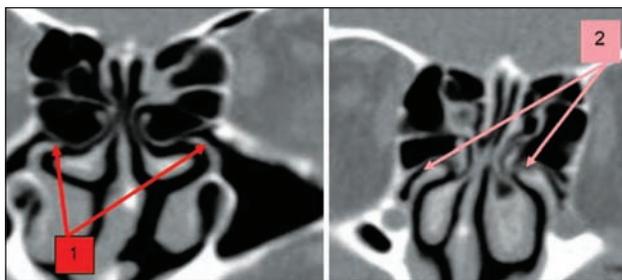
Paranasal sinuses CT scan, coronal bone reconstruction. Free margin deformity of the uncinate process: 1. "hook" shape; 2. "cudgel" shape
